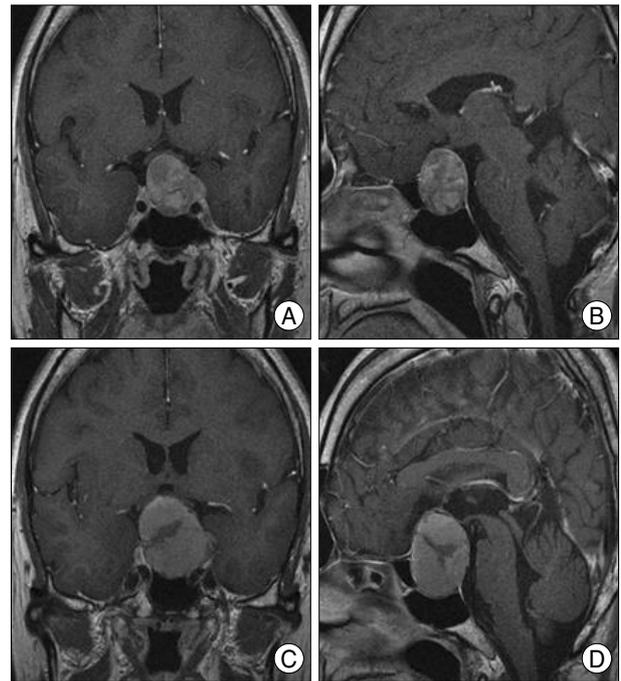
Magnetic resonance (MR) images obtained in case 7. A : Gadolinium enhanced coronal (A) and sagittal (B) MR images obtained 6 months after CyberKnife, Gadolinium enhanced coronal (C) and sagittal (D) MR images obtained 36 months after CyberKnife showing increased size of pituitary adenoma at suprasellar portion.
